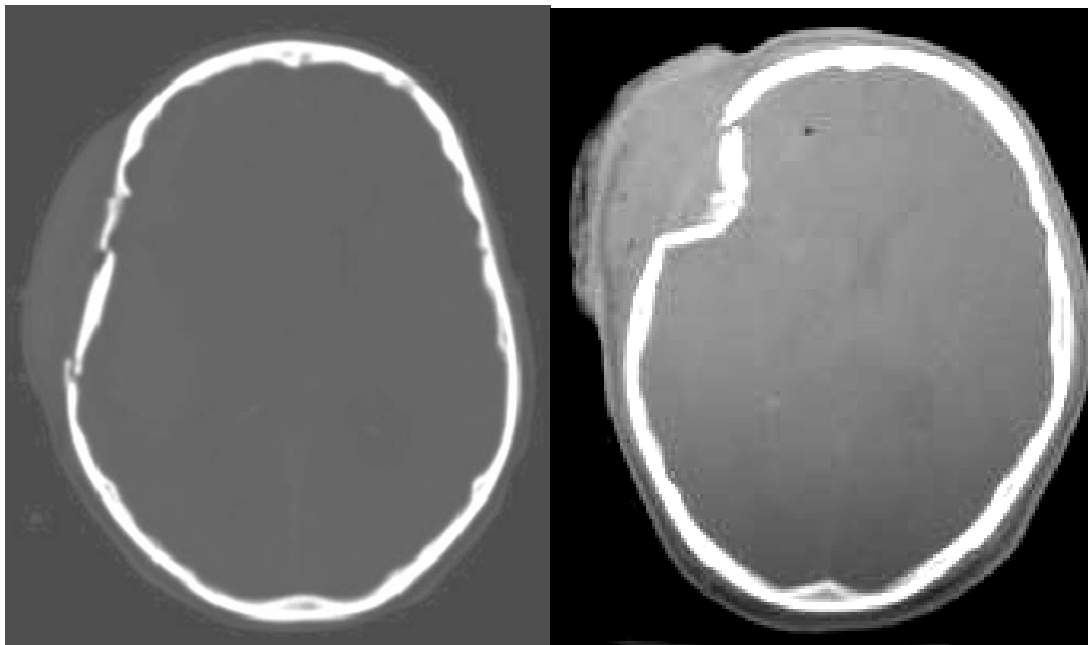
Bone window showing depressed skull fracture (Interpretation of Emergency Head CT Erskine J.et.al 2008).
